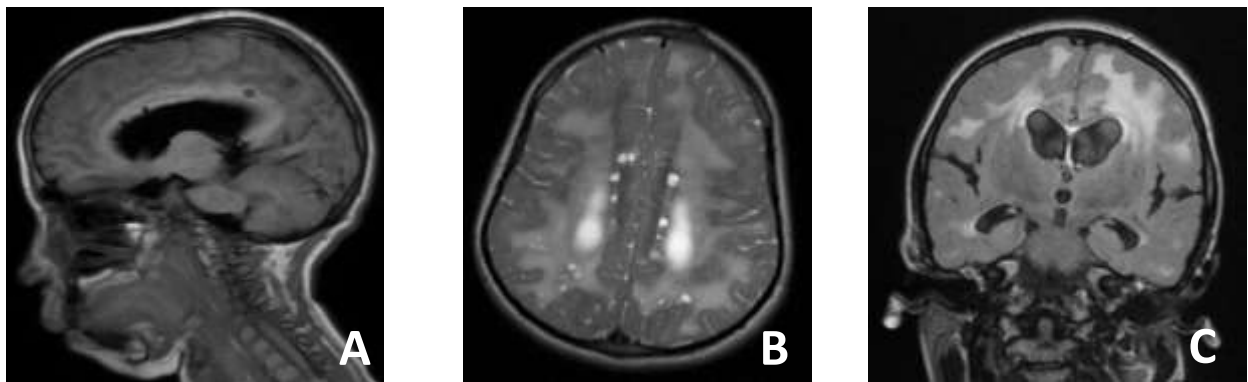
Axial T2- weighted MR image (B), Sagittal T1 (A) and coronal Flair (C) of the brain: marked perivascular space enlargement in the corpus callosum and subcortical white matter, isointense to cerebrospinal fluid at all sequences.
